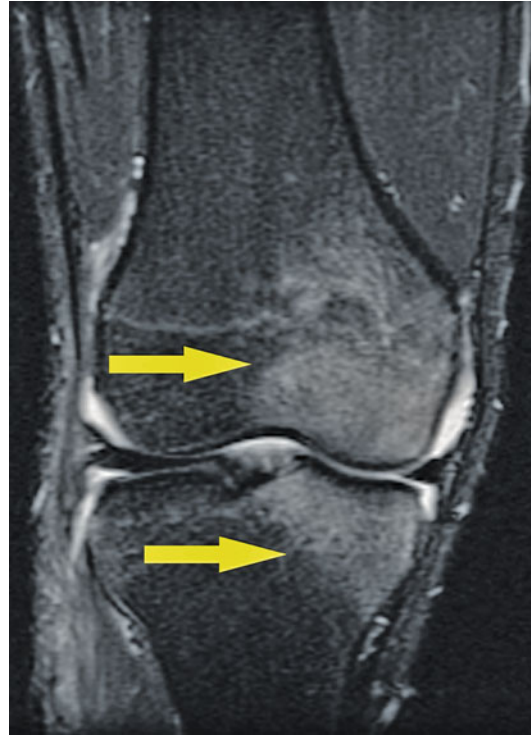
Coronal MRI demonstrating a bone bruise pattern (yellow arrows) associated with combined ACL and PLC injuries
